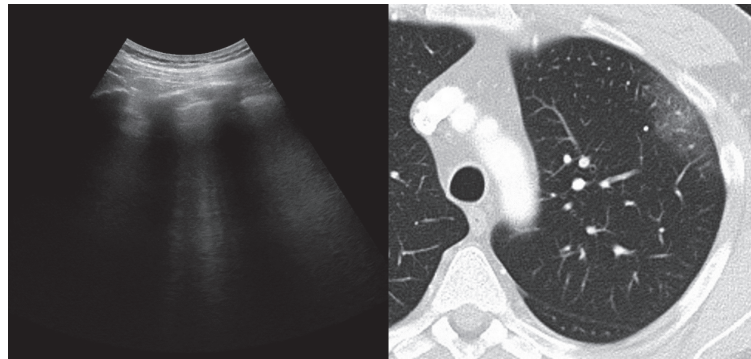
Left panel: LUS demonstrating thickening of the pleural line and intercostal predominantly well-spaced B-lines or B1 pattern. Right panel: CT scan demonstrating bilateral pure GGO.
